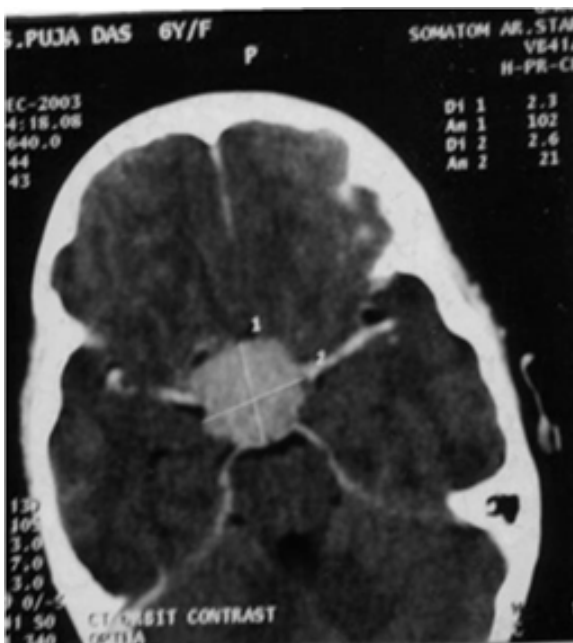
(A,B): Plain and contrast CT of brain showing soft tissue mass with calcification, retrobulbar extension, thickened optic nerve and enhancing suprasellar mass- Retinoblastoma with intracranial extension.
